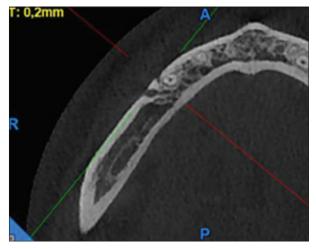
Cone-beam computed tomography image of axial section of MF
